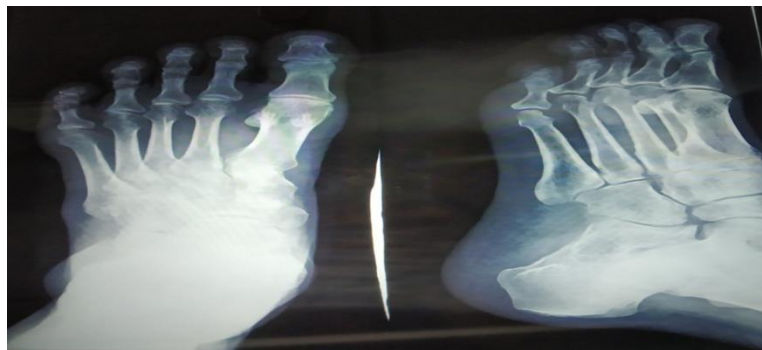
The patient's Left foot x-ray- anteroposterior/oblique view one year after the procedure
